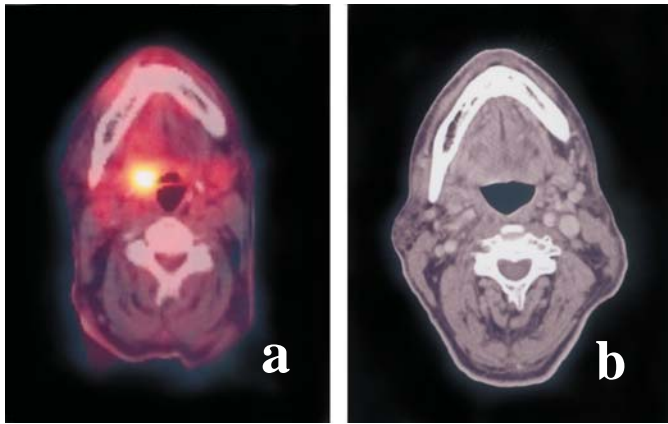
a. Claude's PET scan, September 2006 (observe white spot (carcinoma)); b. CT-scan, February 2007
